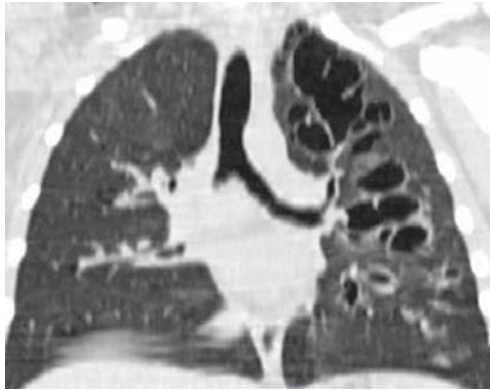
Coronal CT reconstruction shows left upper lobe pneumatocoeles as thin-walled cysts containing air
